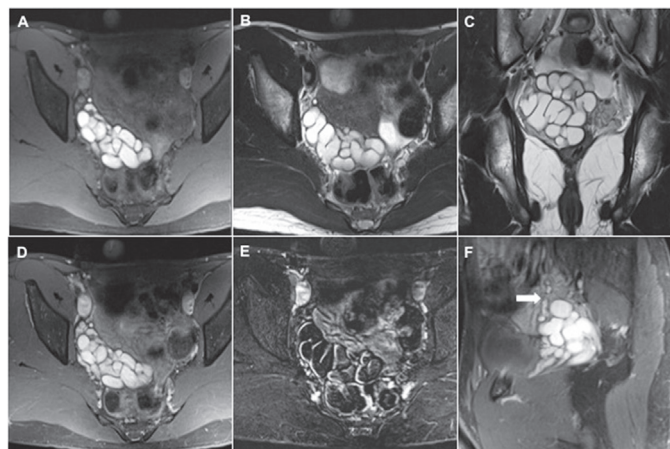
A) Axial T1W shows a hyperintense multiloculated right seminal vesicle cyst, reflecting probably increased concentration of proteinaceous fluid or eventually haemorrhage, B) axial and, C) coronal T2W magnetic resonance imaging demonstrate multiple cystic intercommunicating hyperintense structures. The lesion measures 74x56 mm, D) axial T1W magnetic resonance imaging post-contrast and, E) subtraction images show lack of contrast enhancement, F) parasagittal T1W magnetic resonance imaging showing the tubular remnant ureter (arrow) communicating with the right seminal vesicle cyst
